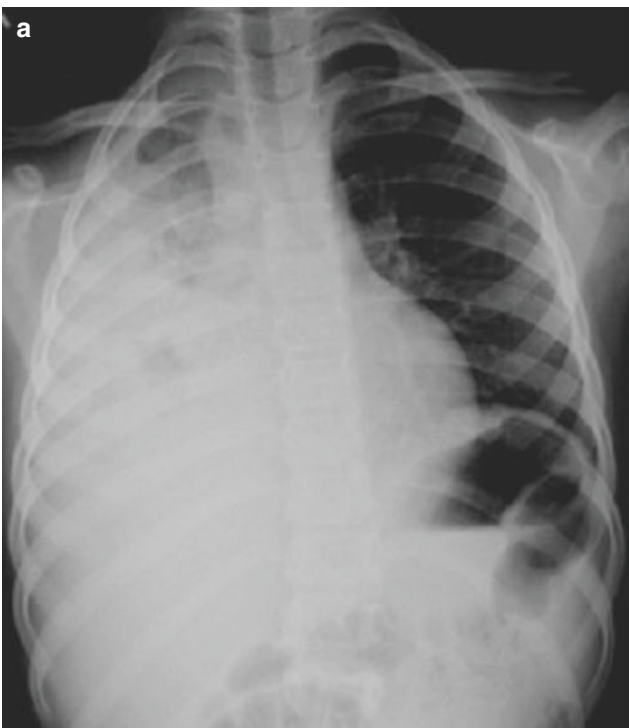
Loculated pleural effusion on supine (a) and decubitus (b) radiographs with no significant change in the configuration or distribution of the effusion
